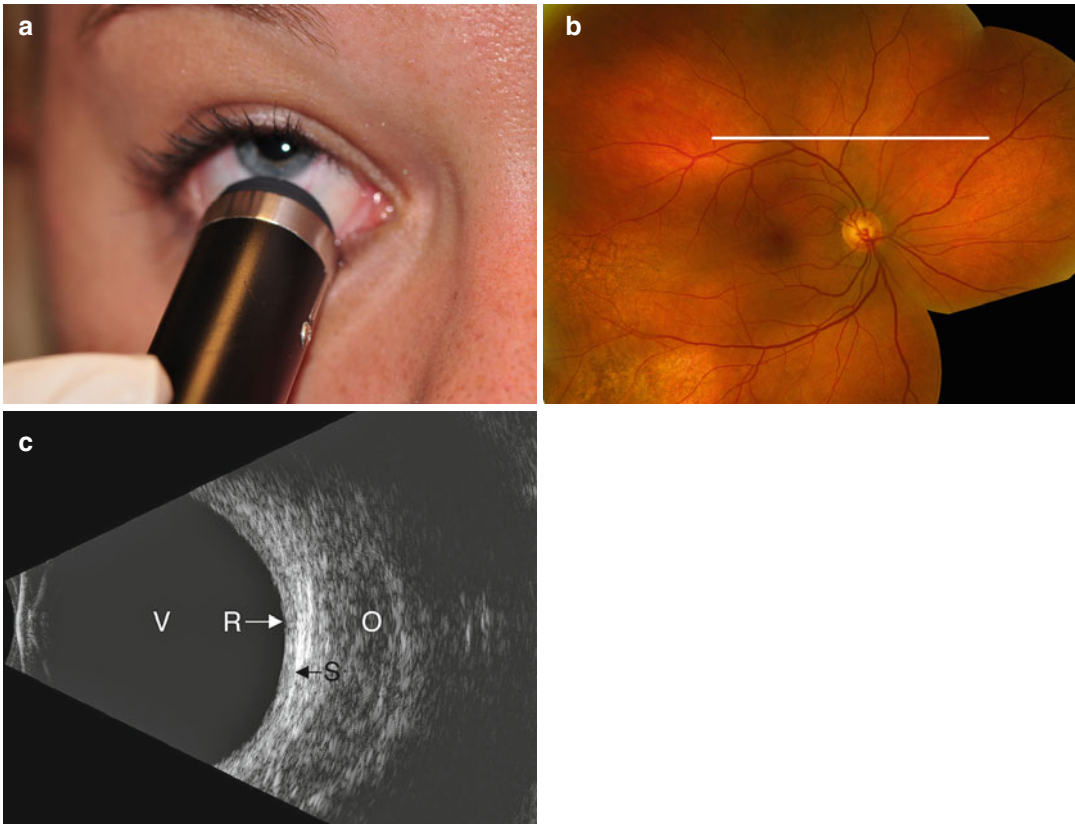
Transverse B-scan position. B-scan probe tip placed on the conjunctiva near the limbus (a). Corresponding ultrasonographed fundus (b, *line*). Resulting B-scan image
